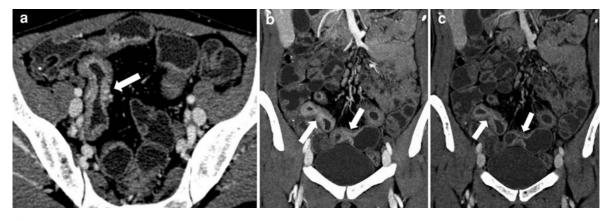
Contrast-enhanced axial (a), coronal with MIP (b) and coronal (c) CT image showing mural "skip" lesion thickening of ileum (*arrow*) with submucosal edema and dilated proximal loops
